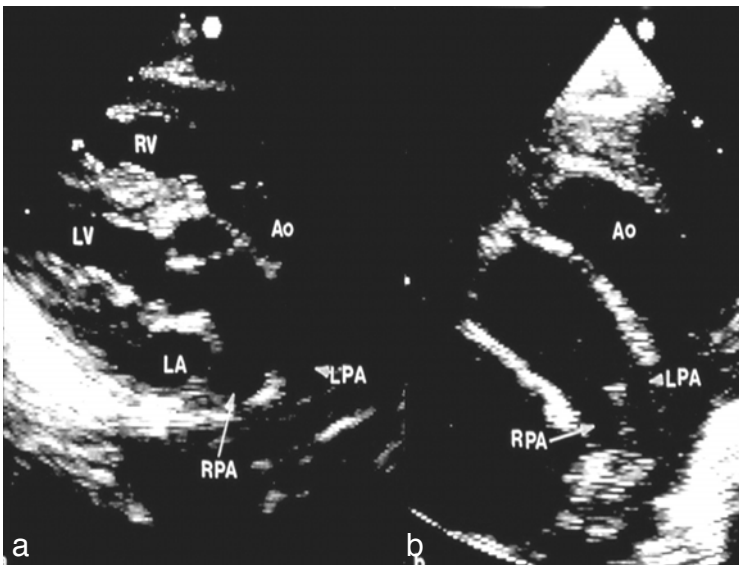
Selected video frames from a 2-dimensional echocardiographic view of an infant with transposition of the great arteries. In a, note the great vessel coming off of the left ventricle (LV) courses posteriorly and bifurcates into left (LPA) and right (RPA) pulmonary arteries. In b, posterior vessel is similarly seen to bifurcate. The anterior vessel is aorta (Ao). LA, left atrium; RV, right ventricle.
